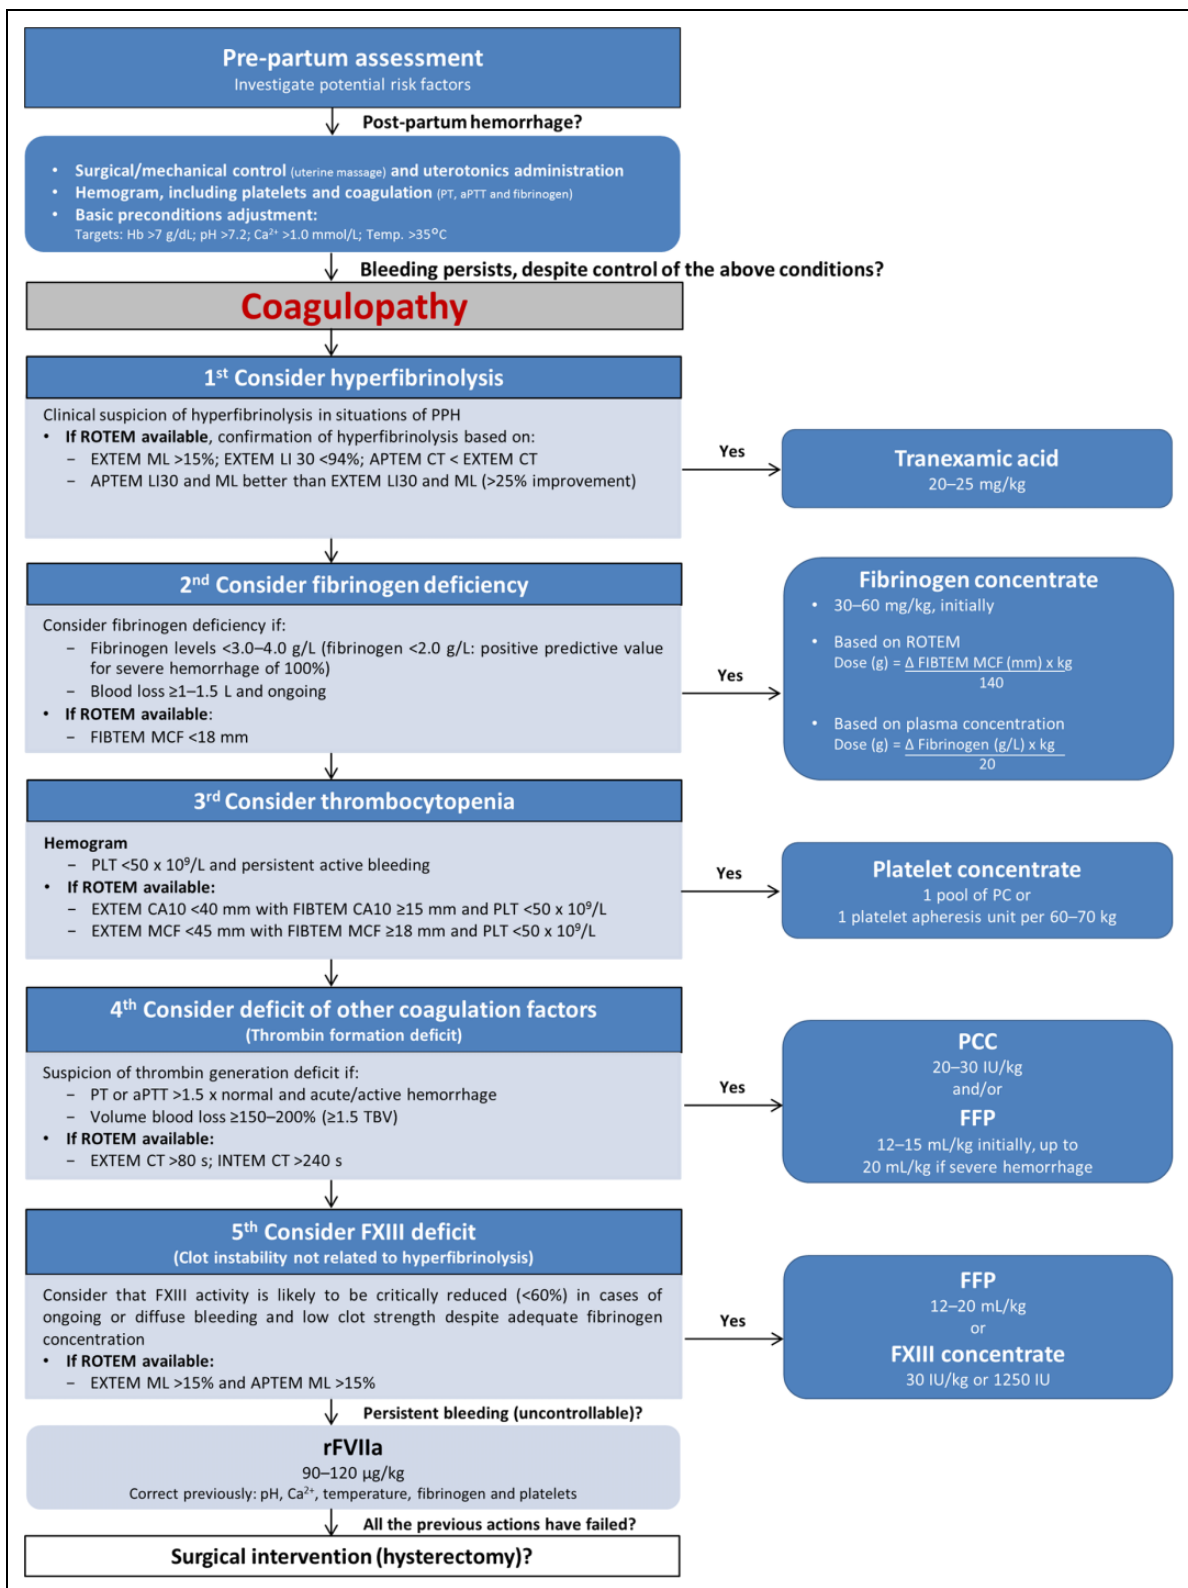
Proposed algorithm for the management of postpartum hemorrhage. aPTT indicates activated partial thromboplastin time; CA10, clot amplitude after 10 minutes; CFT, clot formation time; CT, clotting time; FFP, fresh frozen plasma; Hb, hemoglobin; Hct, hematocrit; LI 30, lysis index after 30 minutes; MCF, maximum clot firmness; ML, maximum lysis; PC, platelet concentrate; PCC, prothrombin complex concentrate; PLT, platelet count; PT, prothrombin time; TBV, total blood volume.
